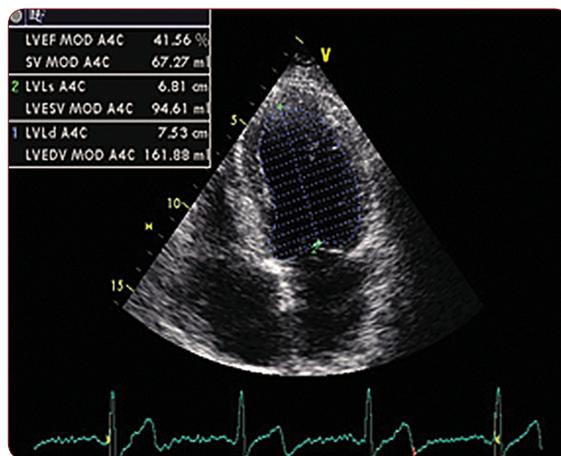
Echocardiographic evaluation of left ventricular ejection fraction at eight years after the surgical cure of the free wall rupture
